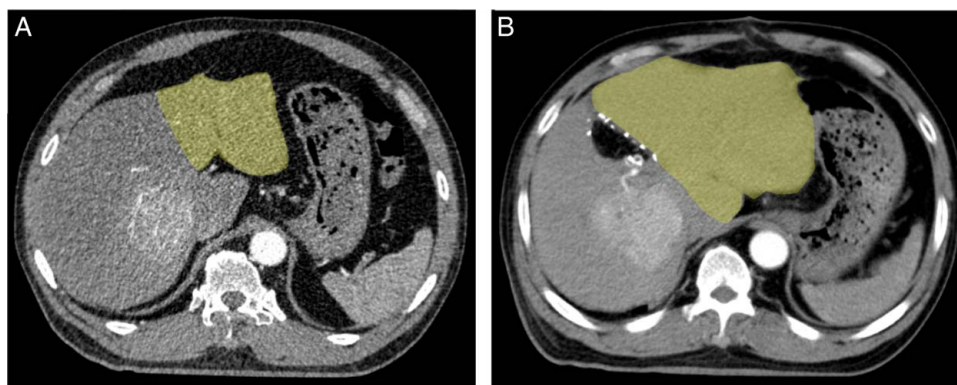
(A) Preoperative computed tomography (CT) image (RLV/BWR: 0.54%). (B) 14th postoperative day CT image (RLV/BWR: 0.93%). The yellow part shows the hypertrophy of left hemiliver.
